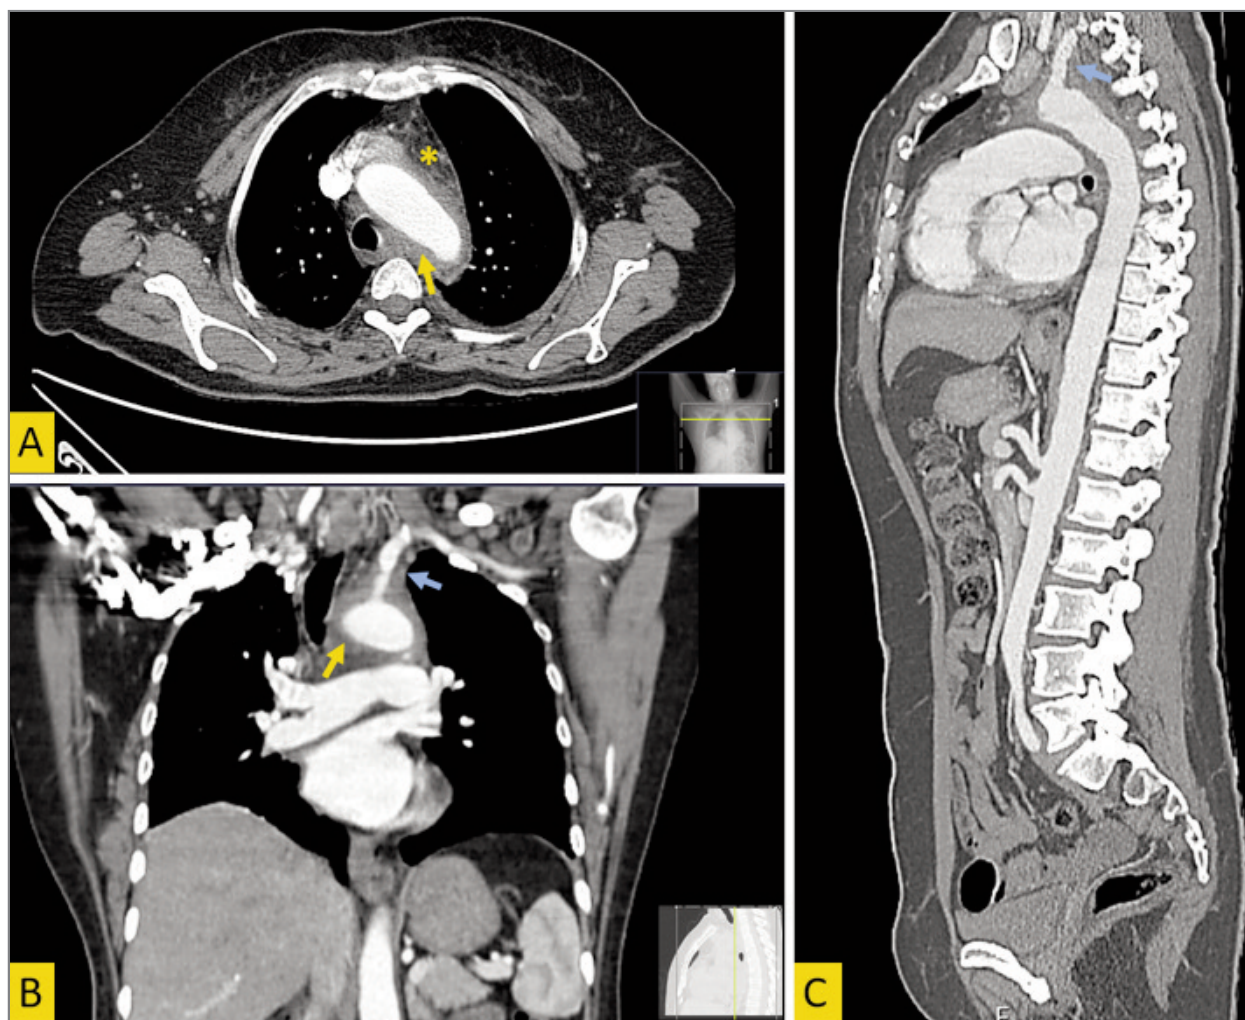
Contrast-enhanced computed tomography (A – axial, B – coronal, and C – sagittal reconstruction planes) shows wall thickening of the aortic arch (yellow arrows) and left subclavian artery (blue arrows) with perivascular fat stranding (yellow asterisk).
